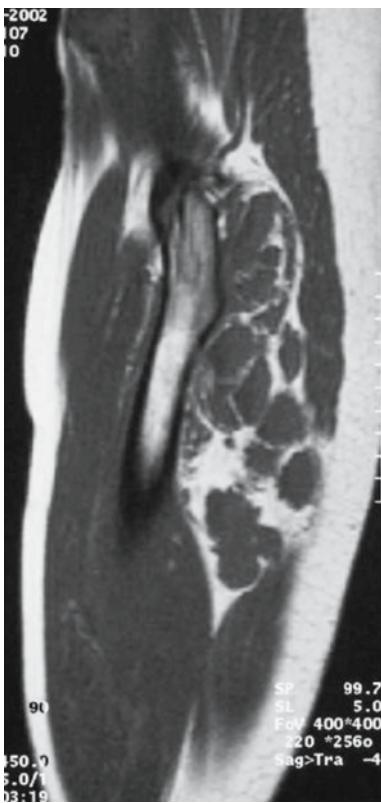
Intramuscular hemangioma in a 40-years-old man. On sagittal T1-weighted images, the signal intensity of the lesion is inhomogeneous. There are central nodular components that are isointense to muscle. The peripheral parts are mainly composed of fatty tissue and are hyperintense to muscle
